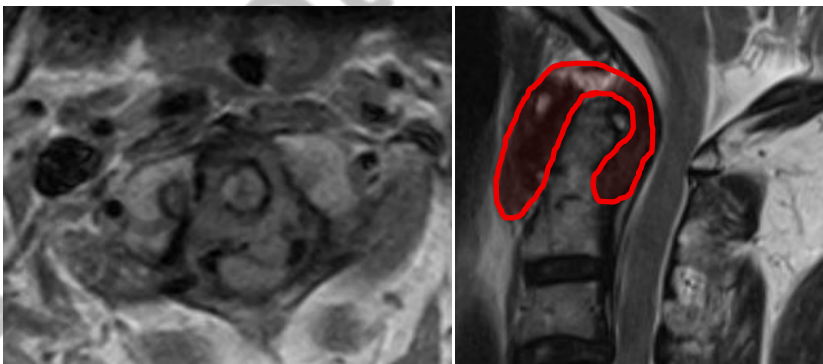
Case 3 (Retro-odontoid Pseudotumor) – Transverse (left) and sagittal (right) cervical MRI, respectively, showing marked thickening of peri-odontoid soft tissues (red-shaded area), with anterior dislocation of the odontoid process and stenosis of the vertebral canal.
